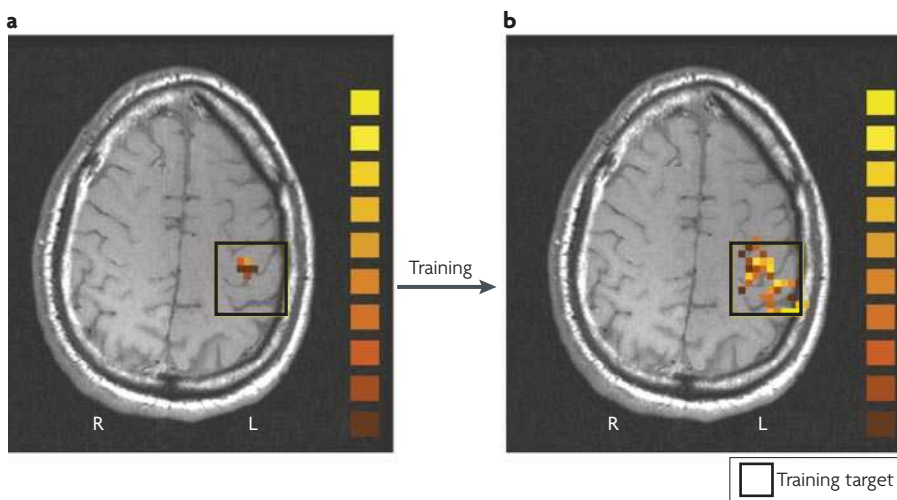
Learned explicit control over activation in a targeted brain region. Functional MRI blood-oxygen-level-dependent (BOLD) activation was measured before and after training during a task that involved subjects imagining moving their right hand. The images show BOLD activation of a representative participant. a | Before training the subject was able to produce a modest level of activation by imagining moving their right hand. b | Following three blocks of twenty minutes during which the subject watched a live signal from this brain region and attempted to increase their control over its activation, there was a significant increase in brain activation that was specific to the target region. The activation patterns are shown here superimposed on a T1-weighted anatomical image. The black square designates the selected region of interest that was used to generate the training signal. Figure reproduced, with permission, from REF. 74 © (2004) Academic Press.
